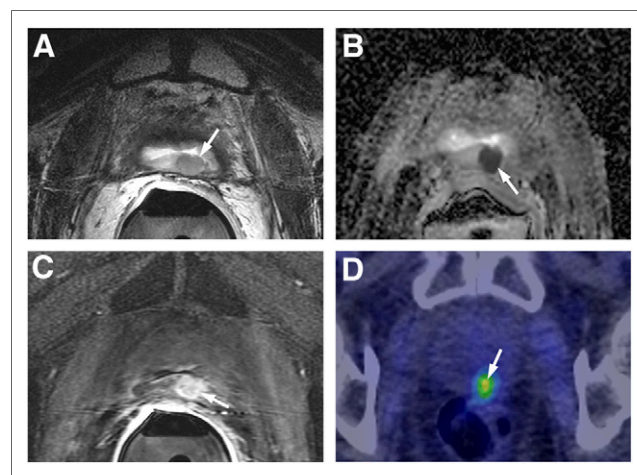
A 60-y-old man with PSA level of 6.3 ng/mL, who underwent RP for prostate carcinoma 3.2 y earlier and then received salvage external-beam radiotherapy and androgen-deprivation therapy. Results of concordant true-positive MR imaging and ¹¹C-choline PET/CT with score for both MR imaging and choline PET/CT of 5 for local recurrence are shown. (A) Axial T2-weighted MR image shows 10 × 11 mm, slightly hyperintense nodule in posterior bladder neck near vesicourethral anastomosis. (B and C) Corresponding areas of restricted diffusion on apparent diffusion coefficient map (arrow) (B) and hyperenhancement on DCE MR imaging (arrow) (C). (D) ¹¹C-choline PET/CT shows choline-avid lesion in prostatectomy bed, with SUVmax of 6.2 (arrow).
